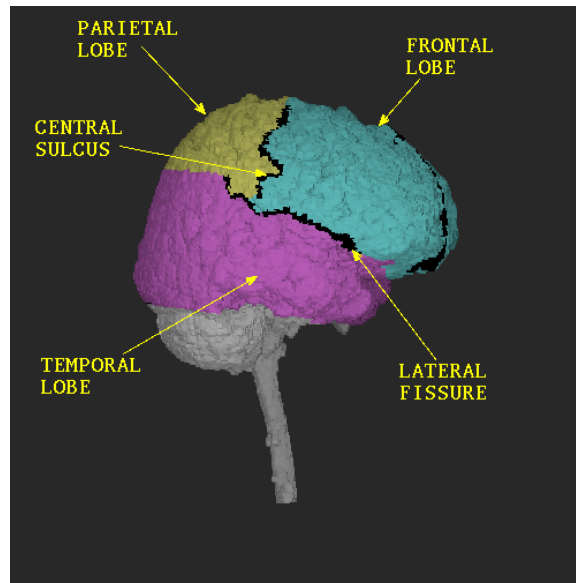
The result of matching a labeled deformable atlas to a morphologically preprocessed MR image of the brain (from [Sandor & Leahy, 1995]).
